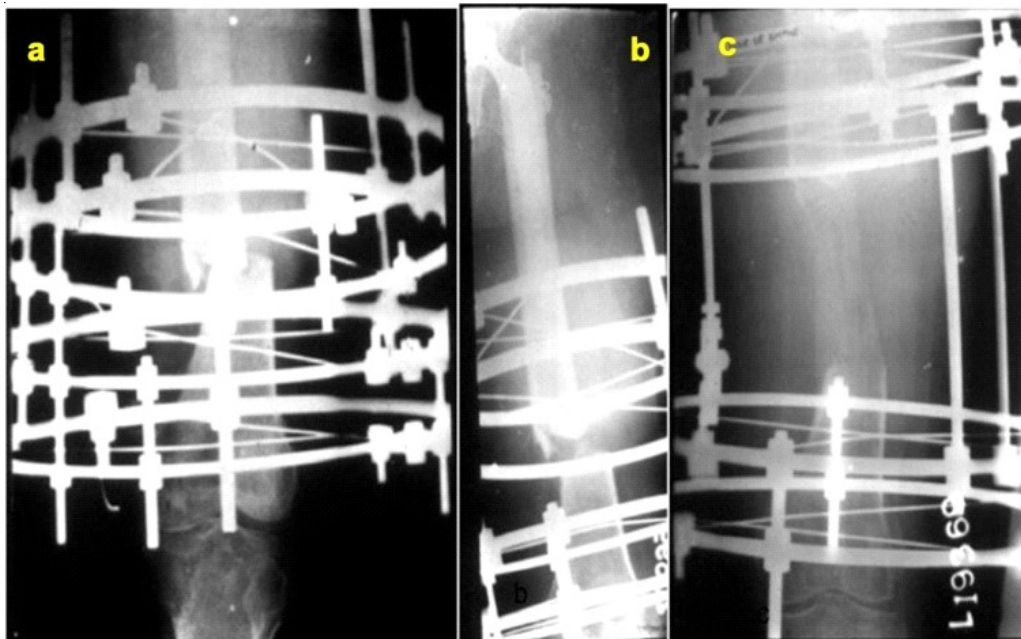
Radiograph of distal femur after Ilizarov Fixation and osteotomy
